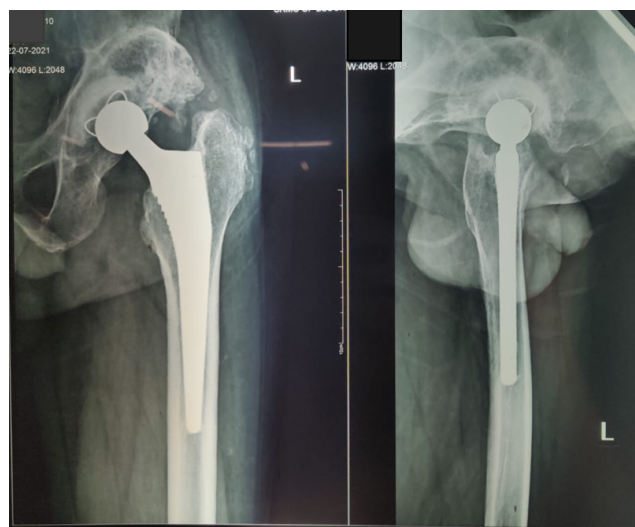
Postoperative left hip AP and Lateral X-rays taken at 5 years follow-up
